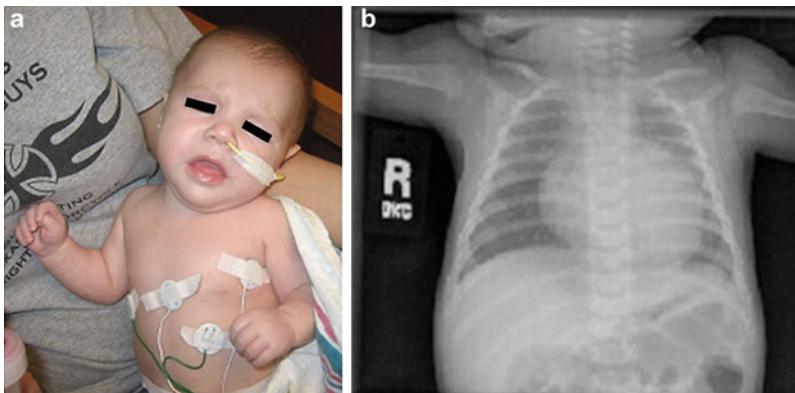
(a, b) A 23-month-old boy (a) was seen because of respiratory distress and heart failure. A chest X-ray (b) showed a large globular-shaped heart. An echocardiogram showed a hypertrophic cardiomyopathy. He was noted to be hypotonic and had an enlarged liver. Muscle biopsy showed excessive glycogen storage with glycogen content 5.6 % (control: 0.94 ± 0.55 % wet weight). Muscle α -glucosidase was deficient (0.01; control: 0.42 ± 0.2 micromol/min/g of tissue). Muscle neutral α -glucosidase was 0.05 (control: 0.12 ± 0.6 micromol/min/g of tissue). Blood acid α -glucosidase was 1.3 (control: 10.0–49.0 pmol/punch/h). Blood neutral α -glucosidase was 52.3 (control: 23.8–132.6 pmol/punch/
